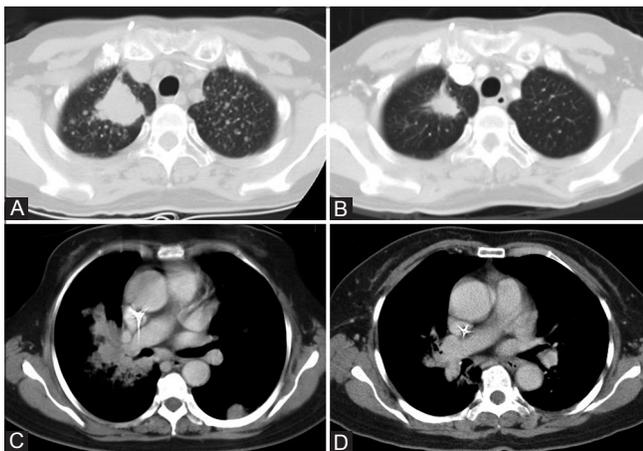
Early responses to *EGFR*-TKI were determined by CT scan performed on Day 14. (A and C) The CT scan images before *EGFR*-TKI treatment for Patient 1 and Patient 16, respectively. (B and D) Marked tumor shrinkage was found after *EGFR*-TKI treatment for 2 weeks in Patient 1 and Patient 16, respectively.
